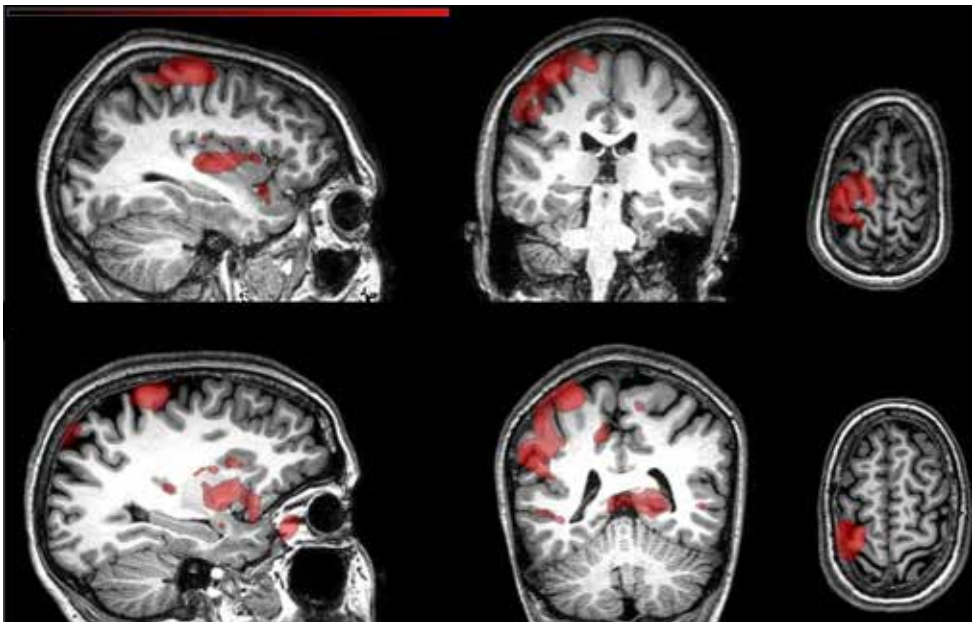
TMS-induced BOLD activation maps for high versus low machine output TMS overlaid on the T1 weighted MRI for 2 participants (top panels denote one participant, bottom panel another participant), in sagittal, coronal and axial view (from left to right).
